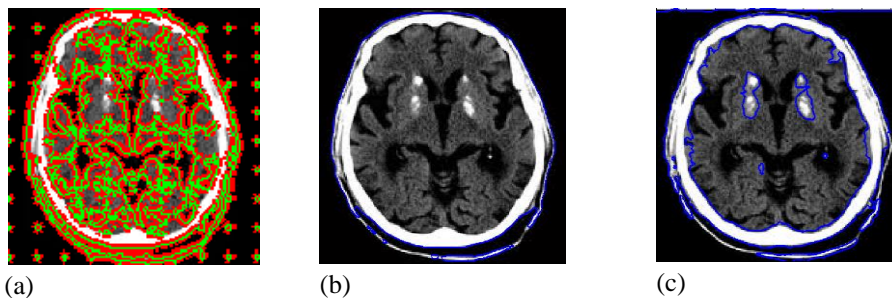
CT scan image of brain segmentation. The final results using the C–V, SGLACM, and proposed methods are shown in the first, second, and third columns when $\alpha=0.077$ $\sigma = 1.0$, respectively.
